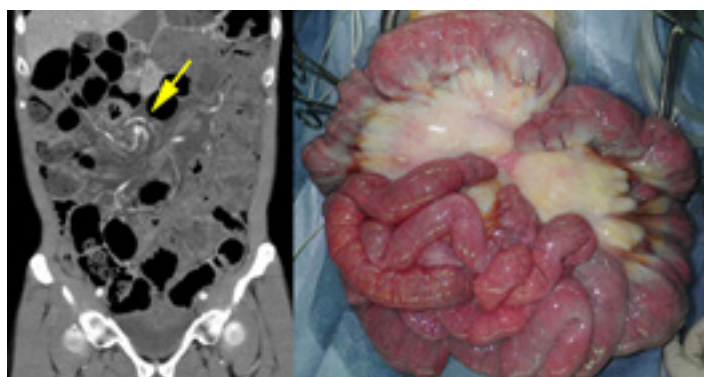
Abdominal computed tomography revealed dilation of small intestine with the lack of contrasts, mesenteric and bowel wall edema, and “clockwise” rotation of the mesentery around the mesenteric vessels (whirl sign) (arrow).
